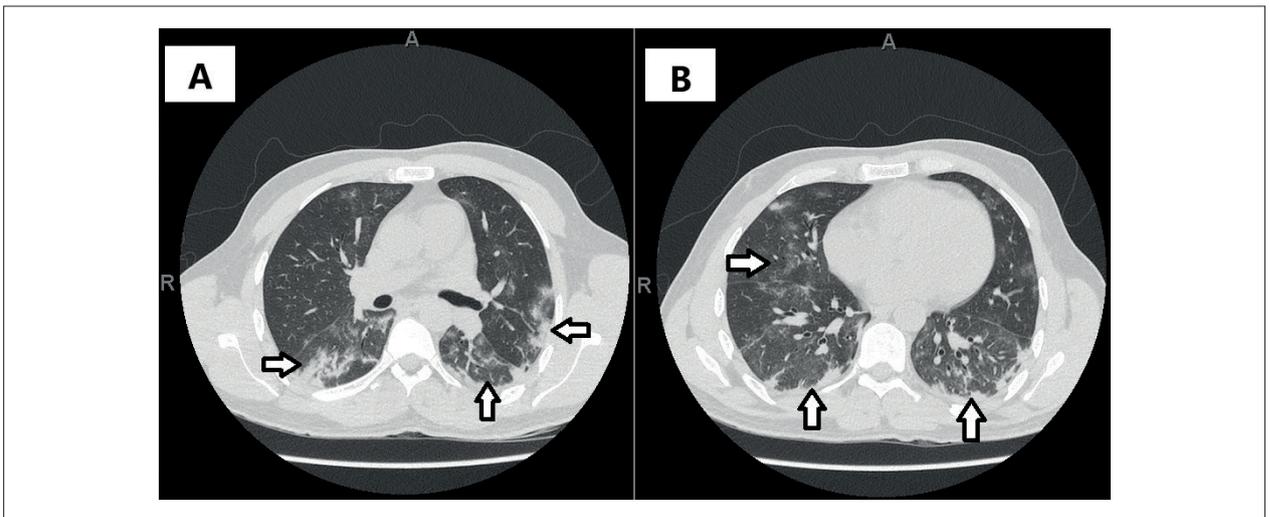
Chest computed tomography showing bilateral ground-glass opacities, predominantly in lung basis, compatible with COVID-19. Involvement of right and left lower lobes, and the lower portion of the right upper lobe (A); areas of ground-glass opacities and peripheral confluent consolidation in lower lobes (B).
